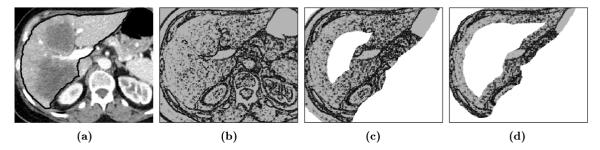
(a) CT of the liver with reference contour. (b) Global cost image of the next slice (shown is the minimum cost value of all (8-neighborhood) connections from one pixel to its neighbors). (c) Locally reduced cost image, the saved computation time is about 44%. (d) Locally reduced cost image with a reduction of computation time of approximately 67%.
